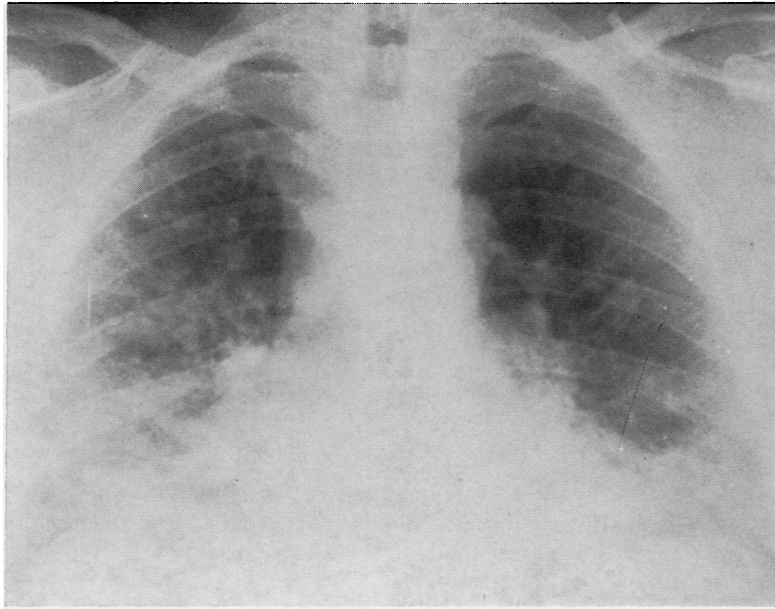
Chest radiograph taken during first admission to hospital shows diffuse shadowing at both bases.*
